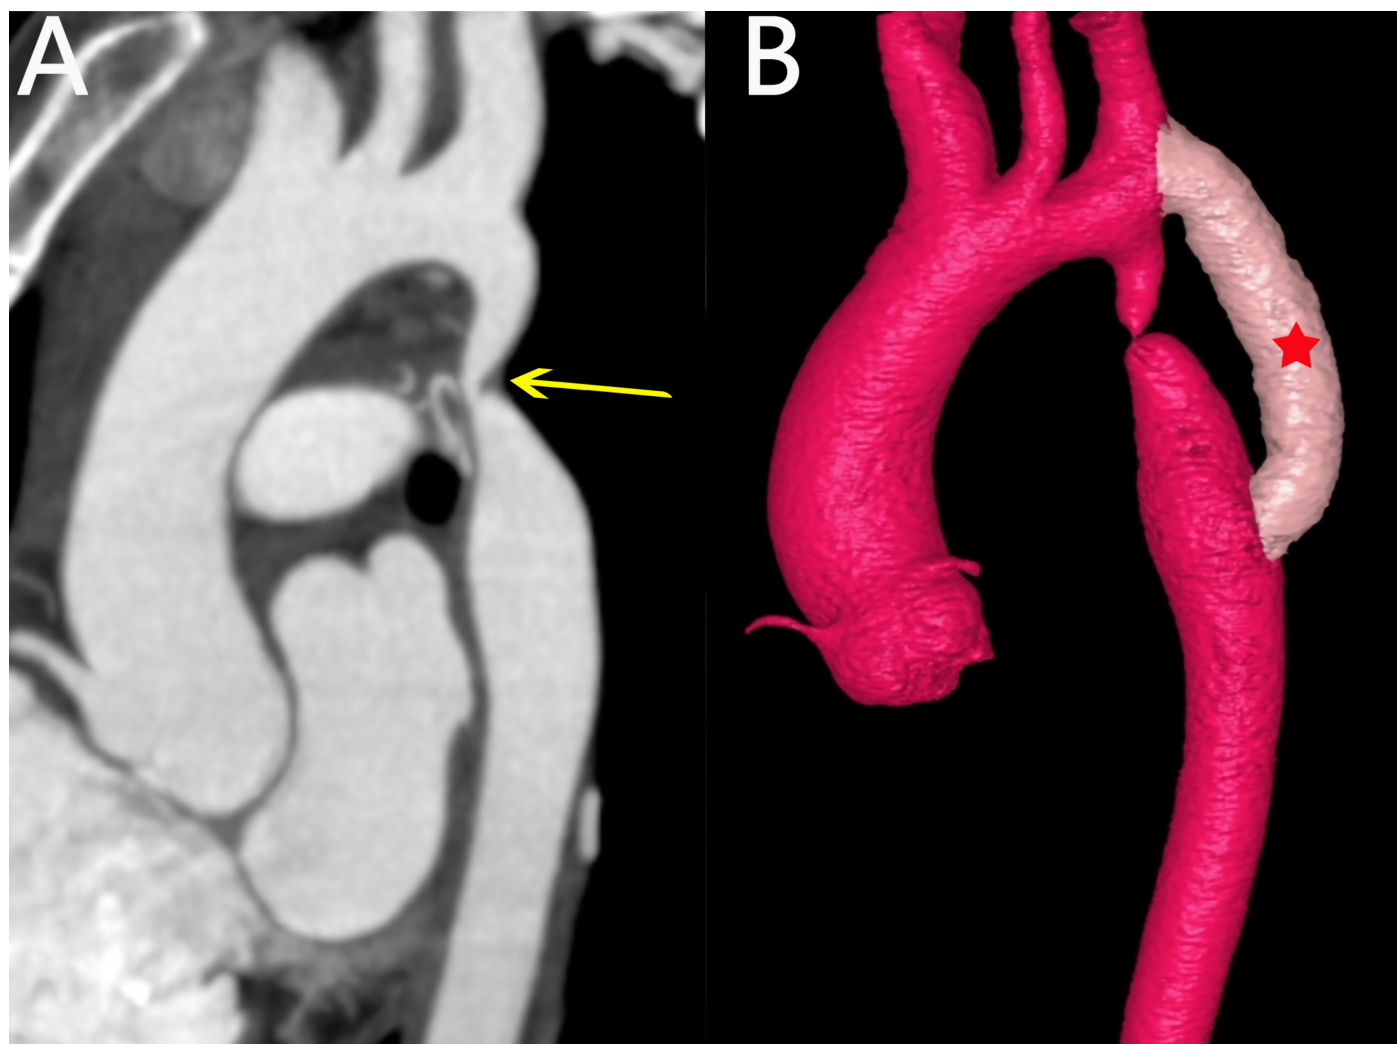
(A) Preoperative computed tomography angiography (CTA) demonstrating severe focal isthmic coarctation (3 mm diameter, 15 mm length; arrow) accompanied by extensive collateral circulation. (B) Twelve-month postoperative CTA confirming patency of the left subclavian-to-descending aorta Dacron graft (star), without evidence of stenosis or pseudoaneurysm.
